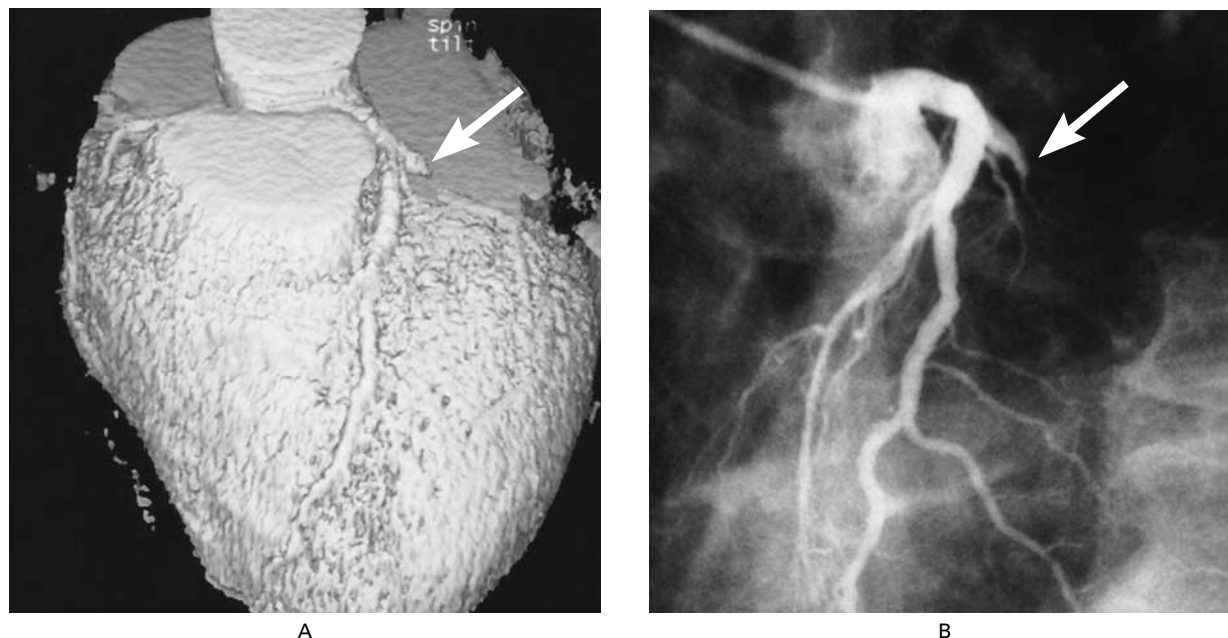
Cardiac Images of a 56-Year-Old Patient with a Complete Occlusion of the Left Circumflex Coronary Artery (Arrow) According to Electron-Beam CT (Panel A) and Coronary Angiography (Panel B).
